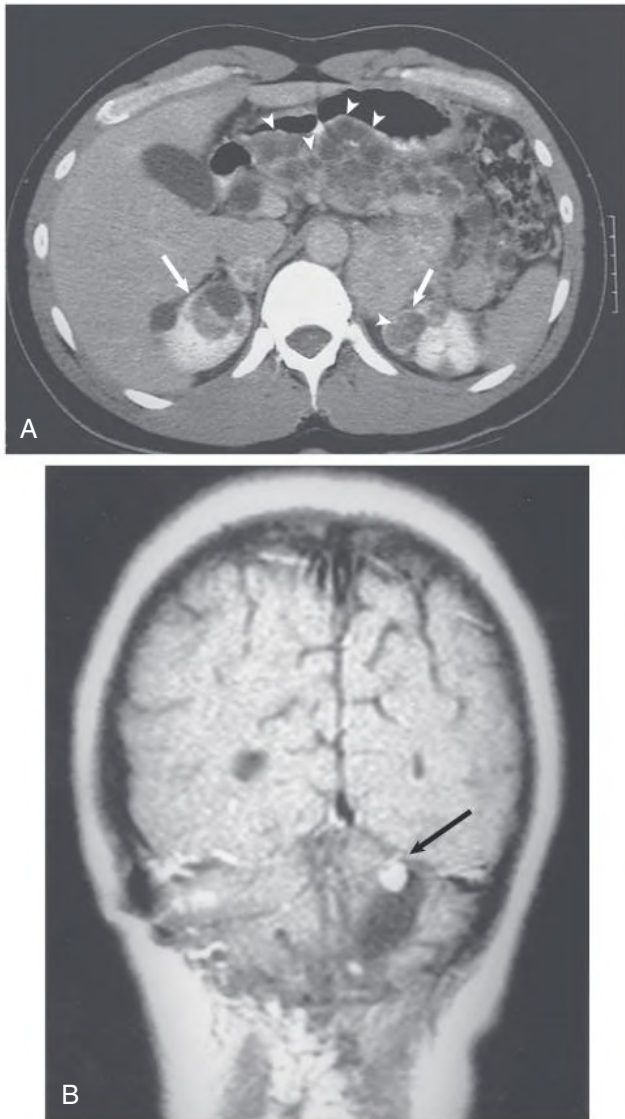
Radiologic Findings Associated With von Hippel-Lindau Syndrome. (A) Noncontrast computed tomography shows massive cystic involvement of the pancreas (*arrowheads*) and bilateral kidney cysts (*arrows*). (B) Contrast-enhanced magnetic resonance imaging shows a right cerebellar hemangioblastoma with a small enhancing mass (*arrow*).
